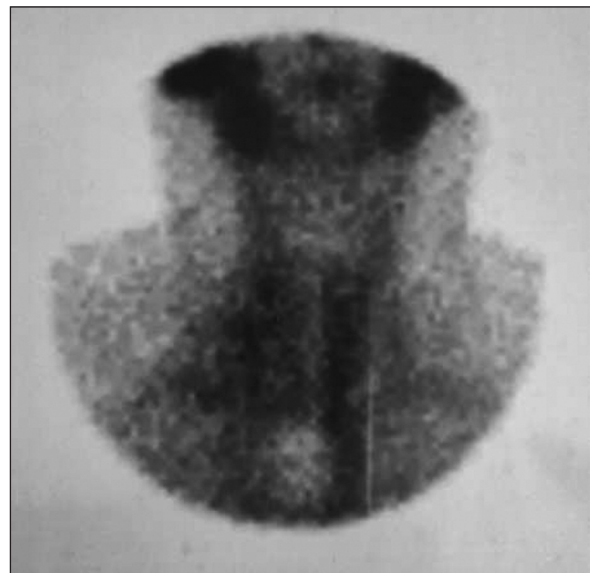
The patient's thyroid scintigraphy.
